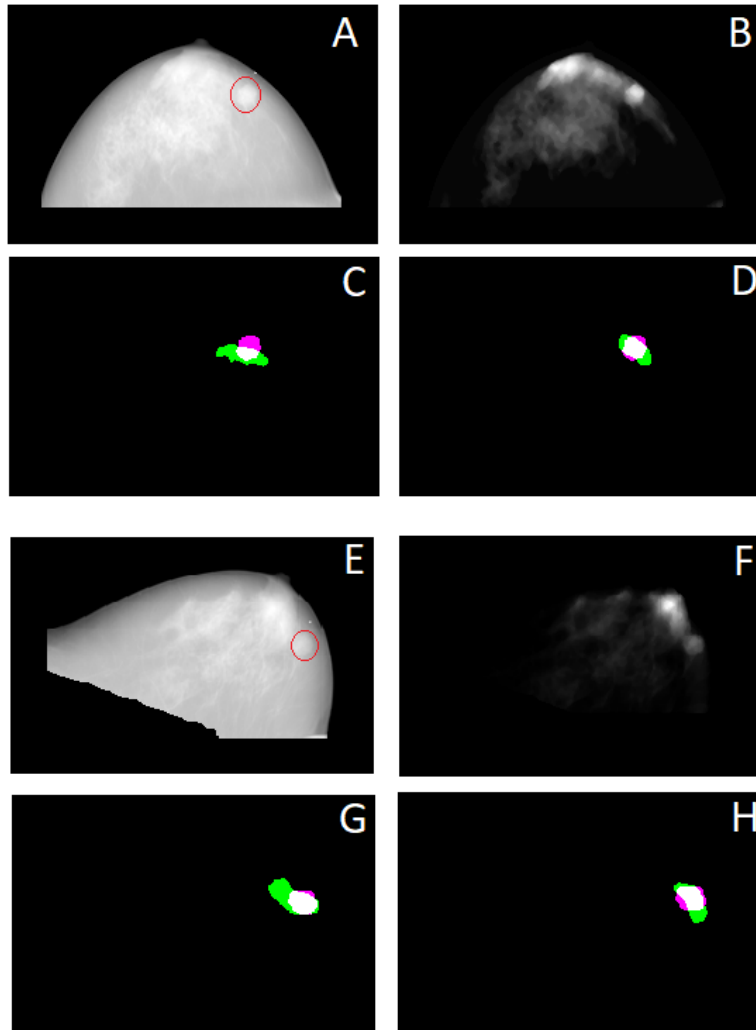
Results of SSD-based MRI to mammogram registration using CAR model: (A) Test mammogram in CC view; (B) thickness of dense tissue for the image in A; (C) Manually (purple) and MRI-based (green) delineation of the breast lesion under the EXR intensity transformation corresponding to A; (D) Manually (purple) and MRI-based (green) delineation of the breast lesion under the TDT intensity transformation corresponding to A; E-H are arranged similarly for the case of MLO mammogram in E. Note that the overlap between manual and automatic segmentations is coloured in white.
